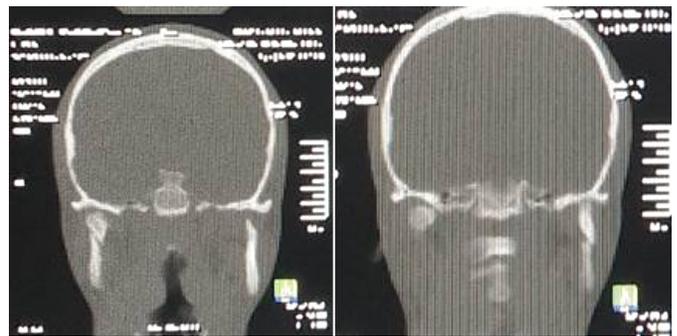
Coronal CT Scan exhibiting bilateral fractures of the condylar process with lateral displacement of the left condyle and medial displacement of the right condyle.
